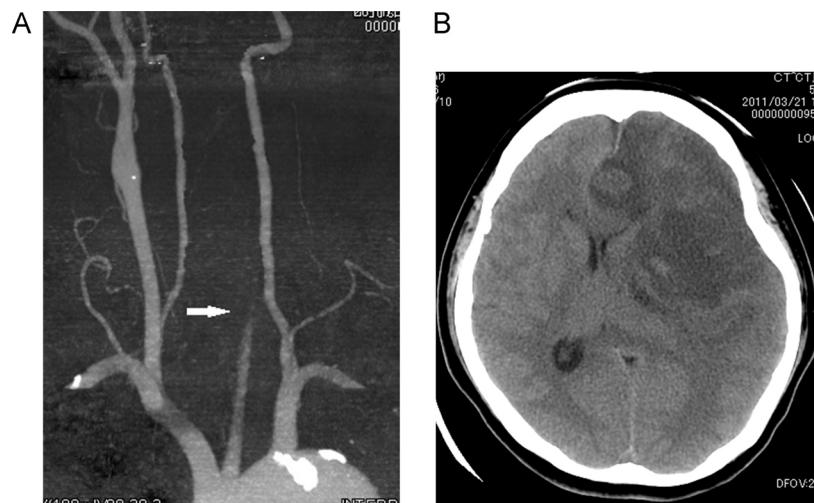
Computed tomography (CT) images when massive cerebral infarction occurred. (A) A reconstructed contrast enhanced CT image of cervical area just after thrombus embolization of left carotid artery. Left common carotid artery was completely occluded (arrow). (B) A brain CT image two days after cerebral infarction. Midline shift was revealed and decompressive craniectomy was performed.
